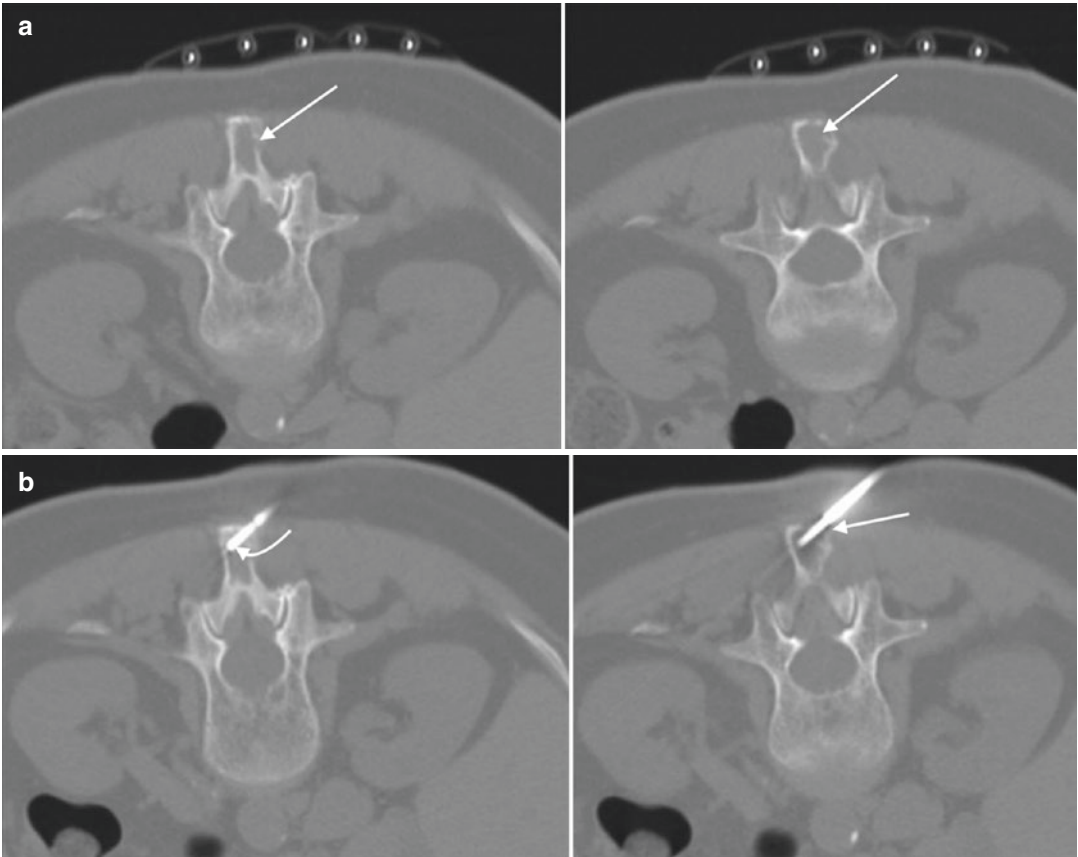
A 74-year-old female with incidental spinous process lesion. Axial CT image (a) in bone window algorithm with a skin grid in place shows trajectory (arrows) for lytic lesion within the spinous process. Axial CT image (b) shows use of coaxial technique with a guide
